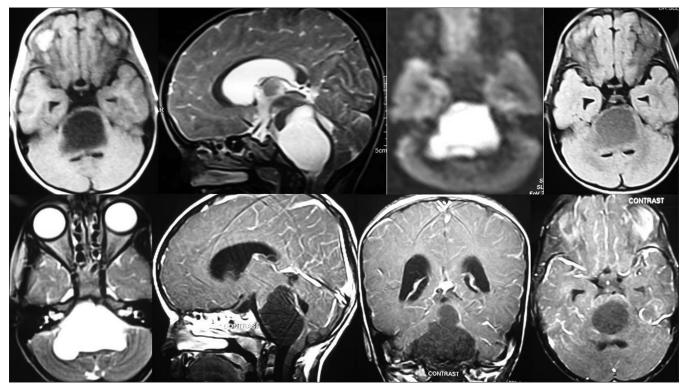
T1 hypointense, T2 FLAIR hyperintense, restriction on diffusion-weighted image with no enhancement on contrast in the region of brainstem suggestive of brainstem epidermoid cyst
